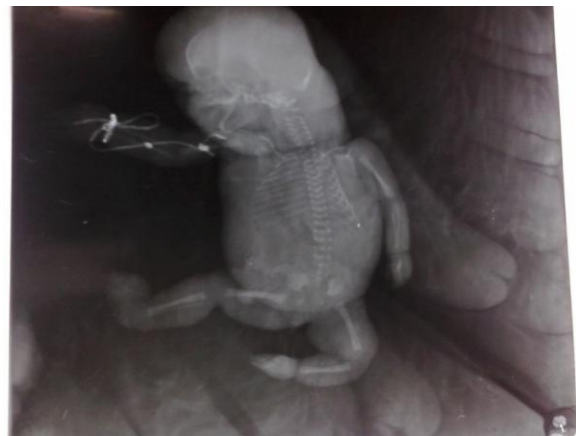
Shows the skeletal x-ray of foetus.
